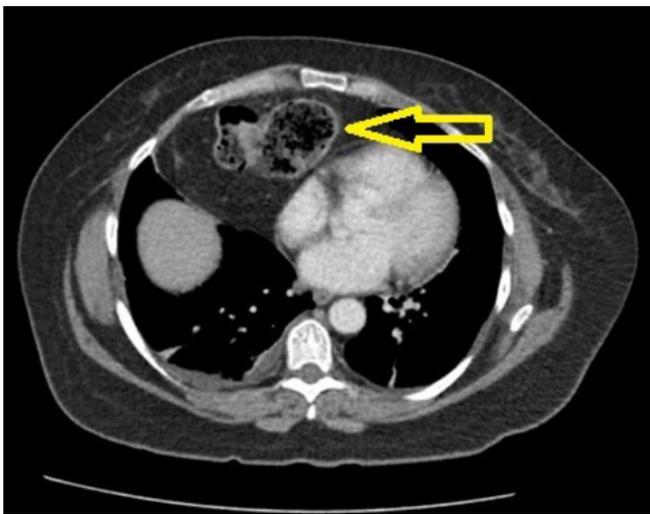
CT Showing Incarcerated Morgagni Hernia. Published with Permission
